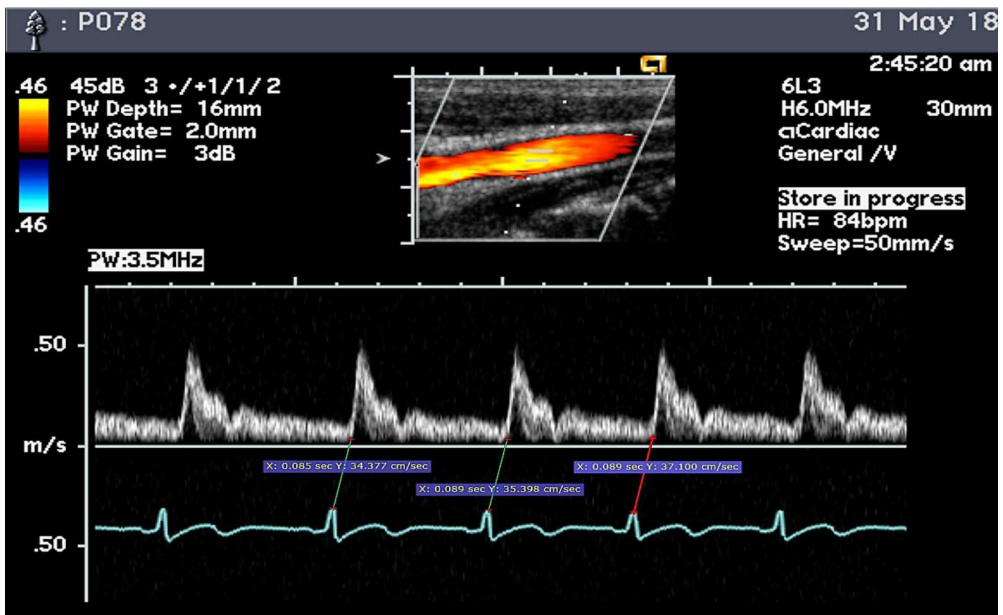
Doppler ultrasound of the pulse wave at the common carotid artery.
